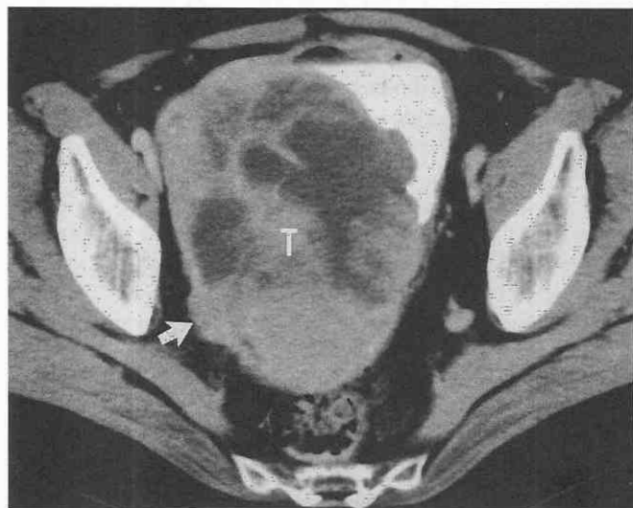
Bladder sarcoma. CT scan in the delayed excretory phase through the bladder shows a partially necrotic tumor (T), a high-grade sarcoma, filling most of the lumen, with an extravesical tumor on the right (*arrow*).
